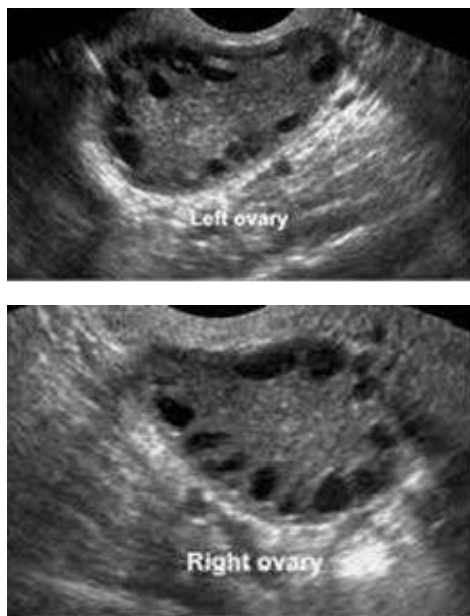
Ultrasound features of the PCOS.
